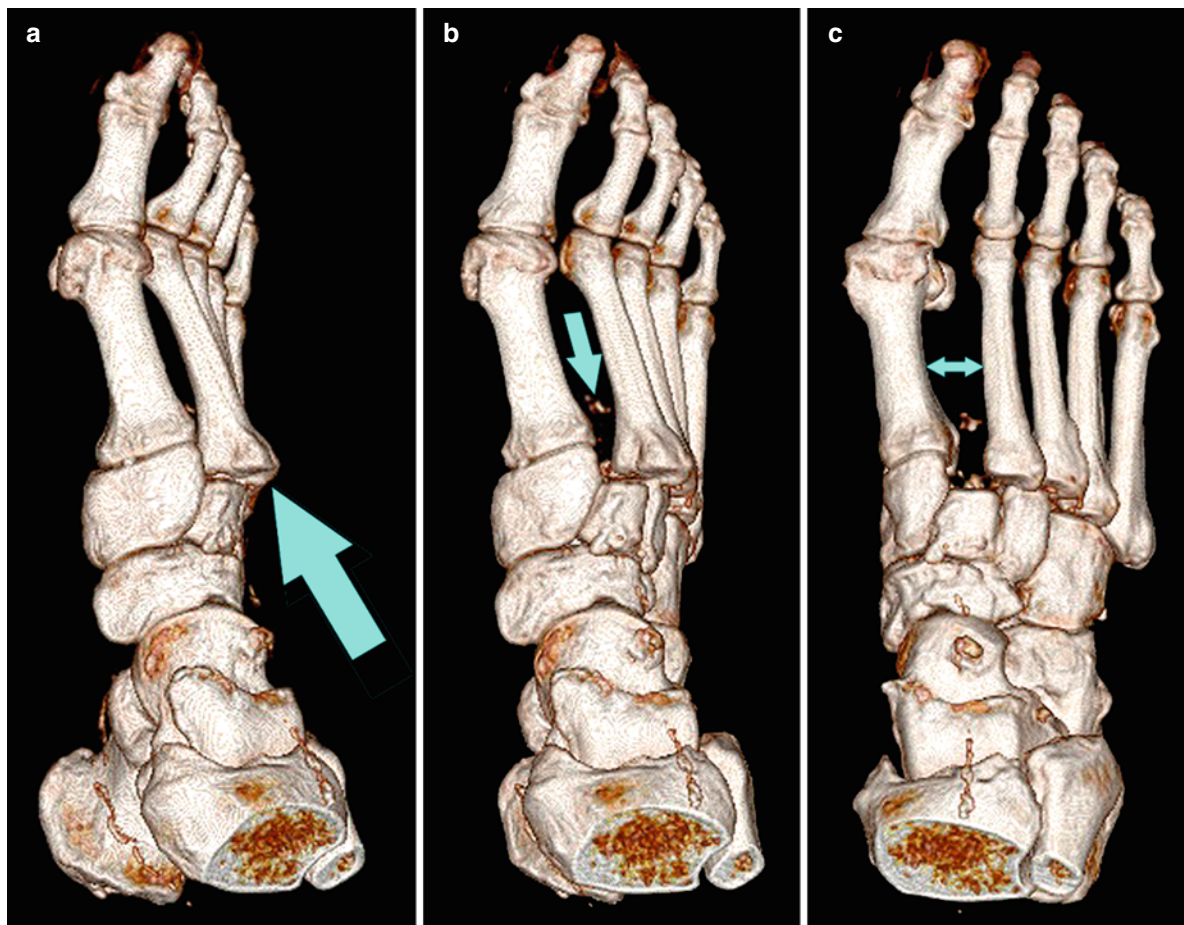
A Lisfranc dislocation fracture is shown as an example for a 3D-reconstruction after CT scan of a foot (a–c), which is helpful for preoperative planning. Dorsal deviation of the metatarsalia II and III are clearly visible (arrow in a). The “fleck
